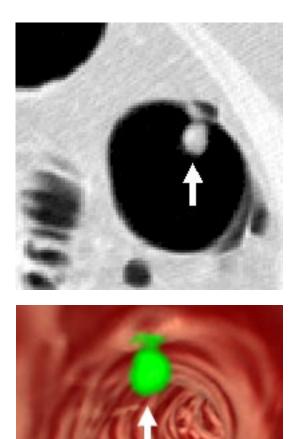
Polyps detected by computer-aided detection (CAD). 10 mm pedunculated polyp in the splenic flexure. (a) axial CT image showing a polyp (arrow) and (b) the 3D endoscopic view of the polyp. The CAD color coding delineates the regions corresponding to the polyp, folds, and colonic wall by green, pink, and brown, respectively. The color coding is based on the shape analysis of the colonic structures performed during the process of automated detection of polyps by CAD.
